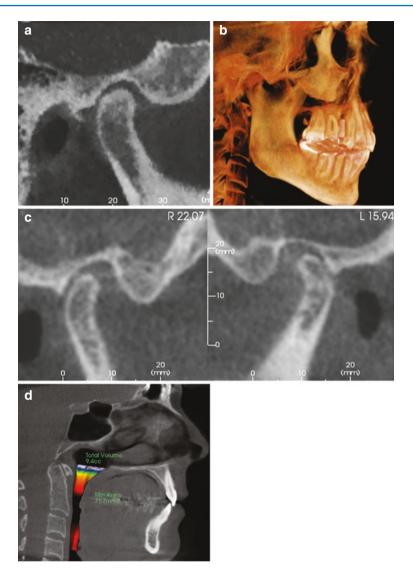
CBCT reformats for common diagnoses for posterior condylar position: (a) disc displacement (MRI verified) and (b–d) functional shift of the mandible. The maxillary central incisors are vertically oriented (b), and this has shifted the mandible and condyles posteriorly (c), which may also contribute to the narrowing of the oropharyngeal airway (d) due to posterior repositioning of the tongue along with the mandible
